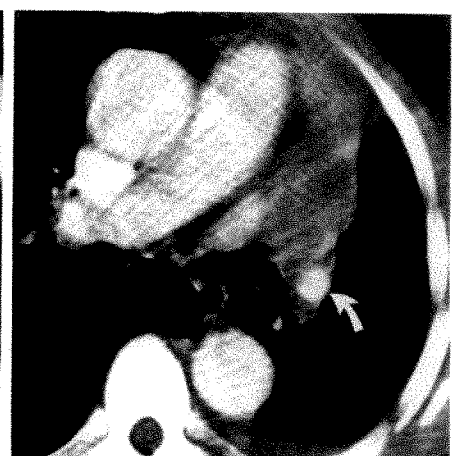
CT localization, left upper lobe collapse.
